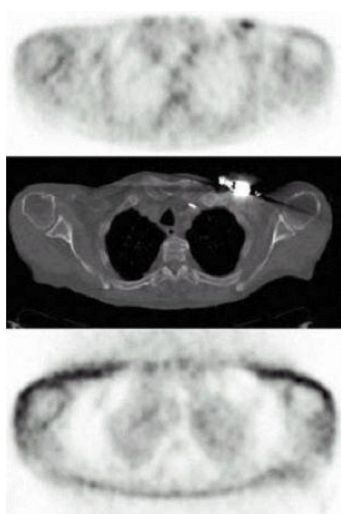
shows Pacemaker Artifact. The top panel shows a CT-corrected PET scan. The middle panel shows the CT scan. The bottom panel shows an uncorrected PET scan. The metal in the pacemaker causes the “hot spot” on the corrected scan ⁽⁴⁾.
